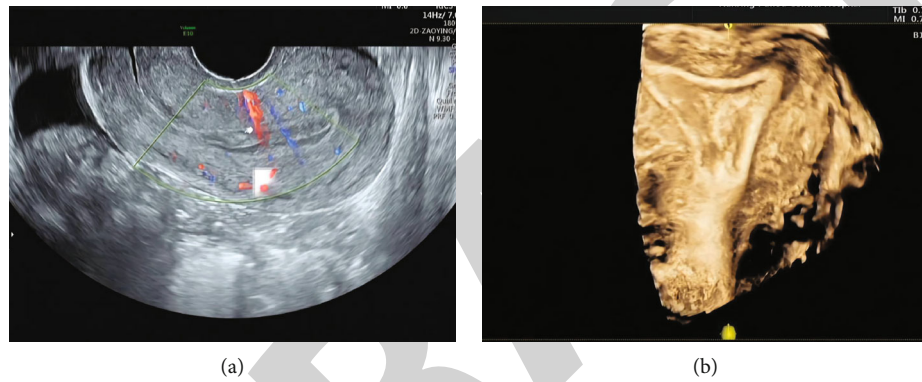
Female, 32 years old: (a) endometrial polyp seen on vaginal ultrasound. (b) 3D-HyCoSy examination reveals endometrial polyps.
